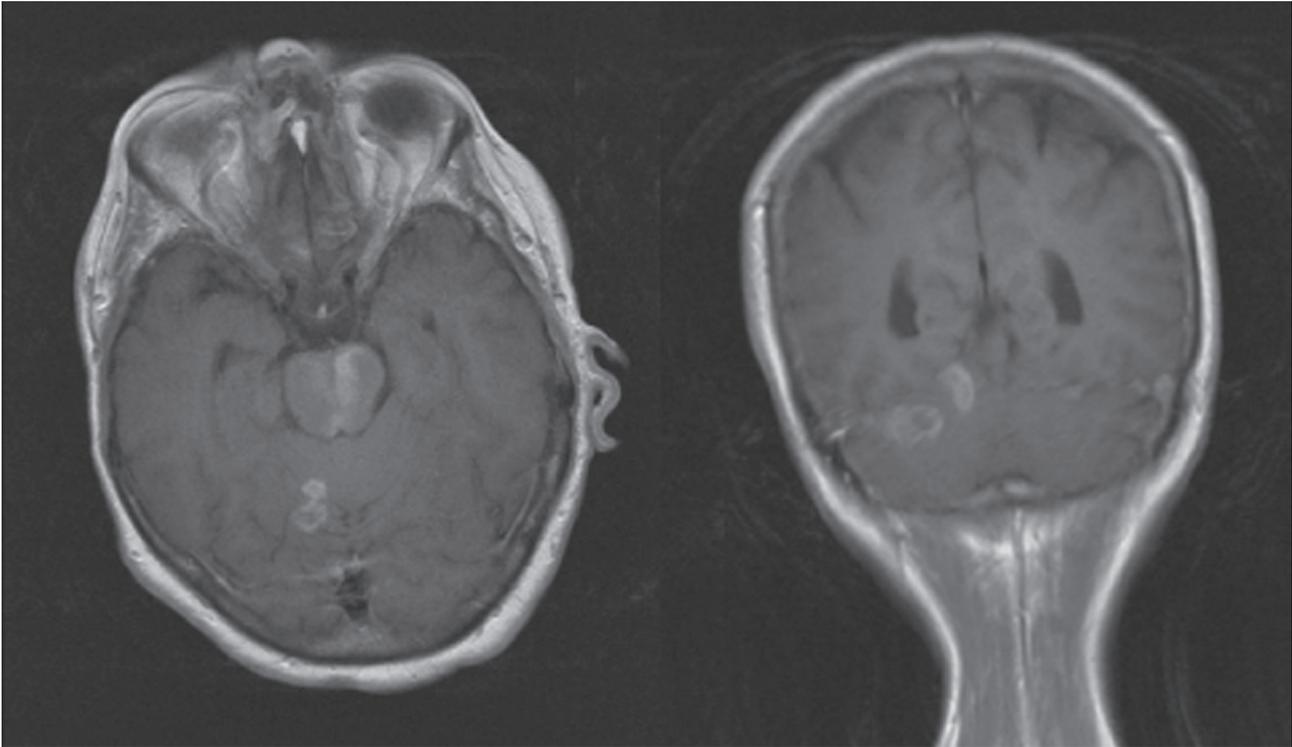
MRI of the brain showing multifocal ring-like hyperintense lesions
